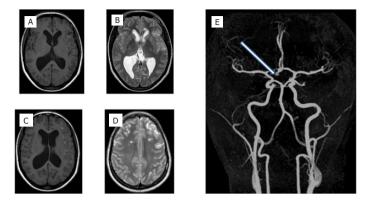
A through C: axial cuts CT brain show diffuse subarachnoid hemorhage in the basal cisterns, sylvian fissures and interhemispheric and peripheral subarachnoid space. Image E : MR angiography show carotid bifurcation aneurysm (see white arrow).
